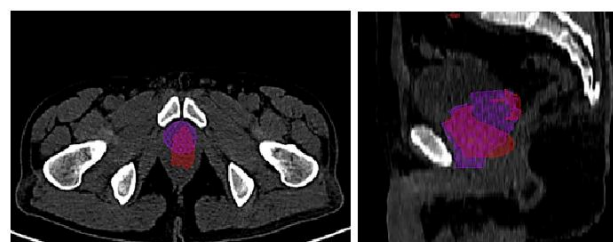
Mapped location of ^{68}Ga -PSMA (red) and CT (purple) shows the difference in place.
